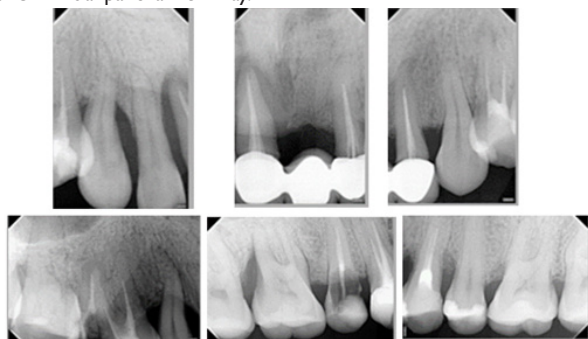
Periapical survey.
